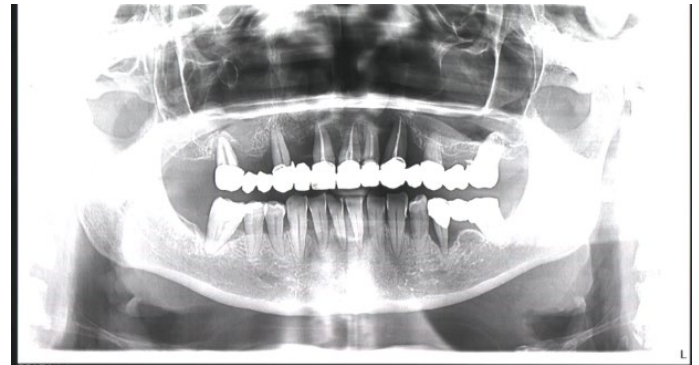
Initial OPT X-ray performed after ultrasonic scaling and individualized oral hygiene instruction. Severe resorption of both maxillary and mandibular alveolar processes is observed, the supporting bone around certain teeth taking a concave shape.
